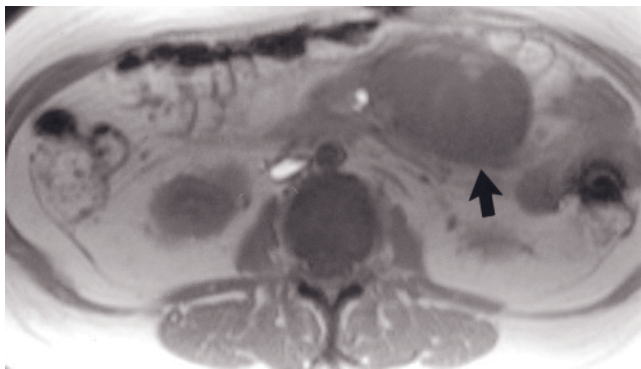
(Continued) Coronal T2-weighted single-shot echo-train spin-echo (*e*), coronal T1-weighted SGE (*f*), transverse T2-weighted fat-suppressed single-shot echo-train spin-echo (*g*), transverse T1-weighted out-of-phase SGE (*h*), transverse fat-suppressed T1-weighted SGE (*i*), and transverse postgadolinium hepatic arterial dominant (*j*) and hepatic venous phase (*k*, *l*) fat-suppressed 3D-GE images in a young pregnant patient with solid and papillary tumor of the pancreas. The tumor (short arrows, *e*, *f*) is originating from the tail of the pancreas (open arrows, *e*, *f*) and depresses the whole pancreas (white long arrows, *e*, *f*) inferomedially. The tumor is well demarcated and compresses the left kidney (white arrow, *g*) and the spleen (white arrow, *h*). The tumor is very heterogeneous. It contains central hemorrhage which demonstrates high signal intensity on out-of-phase (*h*) and fat-suppressed (*i*) T1-weighted SGE images and heterogeneous low signal intensity on T2-weighted images (*e*, *g*). The tumor also contains cystic and necrotic regions, which show markedly high signal on T2-weighted images (*e*, *g*). The solid components of the tumor demonstrate intermediate to moderately high signal on T2-weighted images (*e*, *g*) and low signal on T1-weighted images (*f*, *h*, *i*). The tumor shows mild enhancement on postgadolinium images (*j*, *k*). Note that there are large varices in and around the stomach, and in the splenic hilum due to splenic vein thrombosis. There is an aliasing artifact at the center of transverse T1-weighted images due to the use of parallel imaging. Edema is also detected on the left and posterior body wall (*g*).
